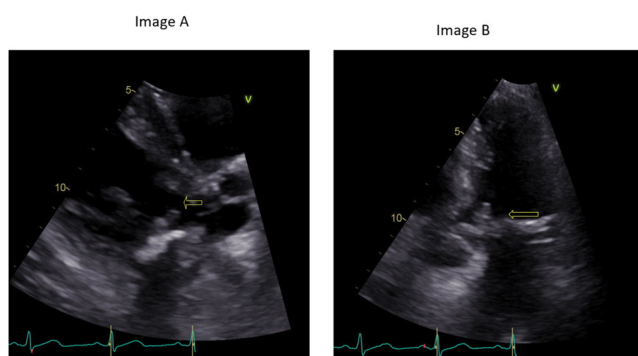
Image A Parasternal long view of the vegetation on the mitral valve, Image B Apical four chamber view of the vegetation on the mitral valve.
